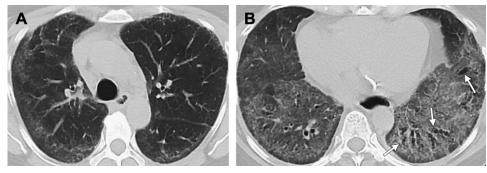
High-resolution (1.25-mm thick sections) CT images obtained through the midthorax (*A*) and lower thorax (*B*) in a 57-year-old woman with scleroderma who presented with cough and shortness of breath. There are bilateral areas of ground-glass opacity with a peripheral distribution in (*A*) and lower lobe predominance (*B*), as well as reticular markings and traction bronchiectasis (*arrows*), all compatible with a nonspecific interstitial pneumonia (NSIP) pattern.
